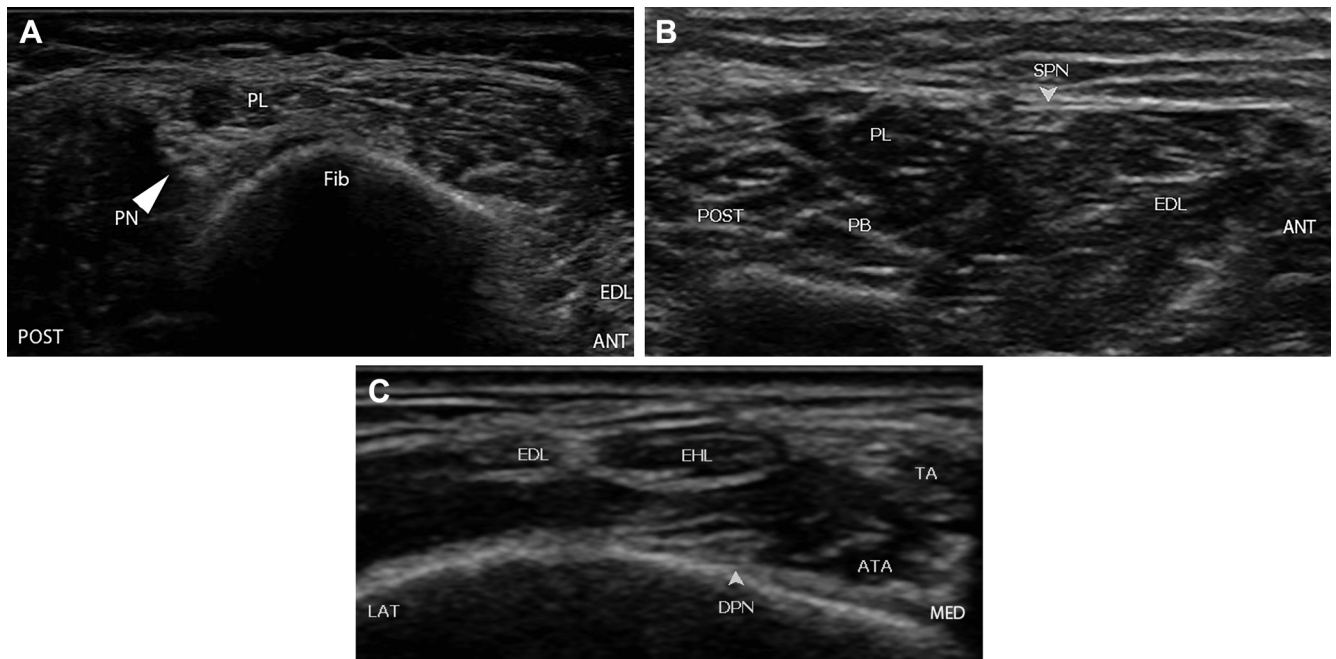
(A) Short-axis ultrasound image of the peroneal nerve as it passes under the peroneus longus tendon at the fibular head. (B) Short-axis ultrasound image of the superficial peroneal nerve as it pierces the crural fascia at the junction of the anterior and lateral compartment in the distal third of the lower leg. (C) Short-axis ultrasound image of the deep peroneal nerve as it courses superficially in the distal lower leg. Arrowhead = nerve; PN = peroneal nerve; PL= peroneus longus tendon/muscle; EDL = extensor digitorum longus tendon/muscle; SPN = superficial peroneal nerve; PB = peroneus brevis muscle; DPN = deep peroneal nerve; EHL = extensor hallucis longus tendon; TA = tibialis anterior tendon; ATA = anterior tibial artery; POST = posterior; ANT = anterior; MED = medial; LAT = lateral.
